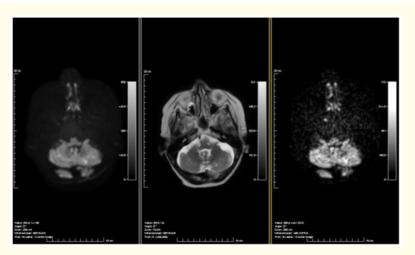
Bilateral cerebellar punctiform acute ischemic infraction with on the left image FLAIR hyperintensity, on the middle image T2 hyperintensity and on the right image diffusion weighted restriction.
